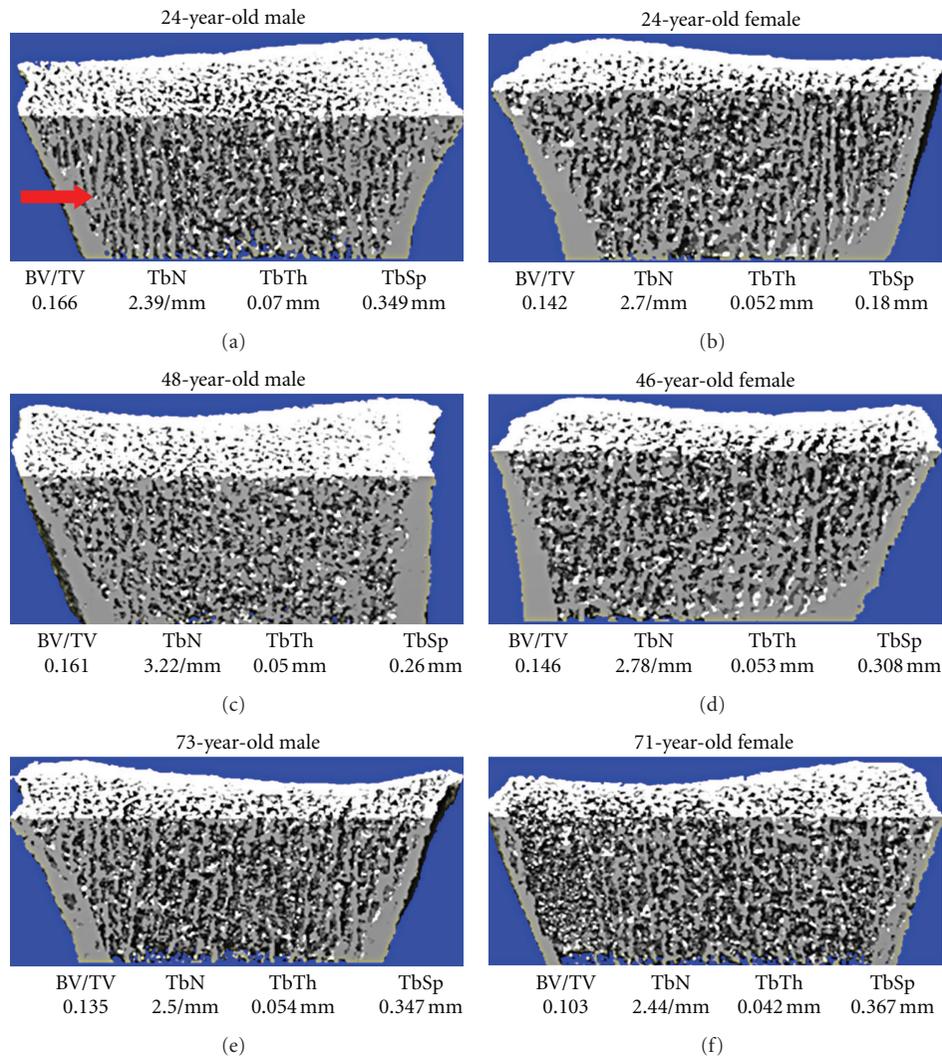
Representative reconstructions of high-resolution peripheral quantitative computed tomography images from young, middle-aged, and elderly men (left) and women (right). Values for trabecular microstructural variables for each subject are also provided. The arrow indicates the prominent plate-like trabeculae in the young man, which are less prominent or absent in the other images. Images were obtained using the initial prototype of the HR-pQCT scanner. (Figure is reprinted with permission from Khosla et al. [8] ©2006 American Society for Bone and Mineral Research).
